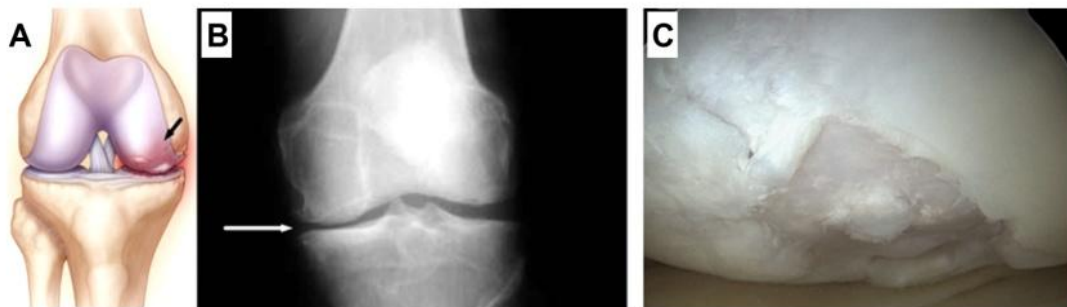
Osteoarthritis (arrow) of the medial side of the knee (A) and radiograph showing osteoarthritis (B), with narrowing of the medial joint space [3]; cartilage defect (C) [95].
